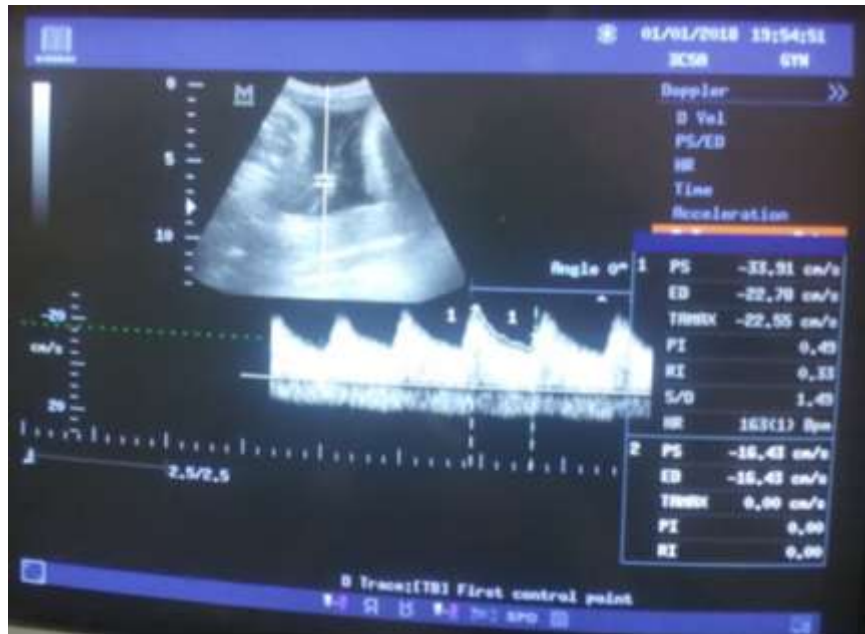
a) shows color Doppler umbilical artery waveform at 38 WKs
